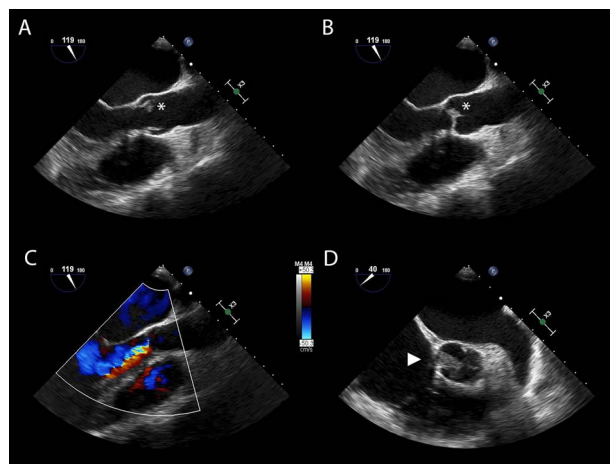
Transoesophageal echocardiography: Long-axis views of the left ventricular outflow tract and aortic valve in systole (A) and diastole (B) showing an echogenic mass in the non-coronary cusp of the aortic valve (indicated by asterisk). This was associated with moderate aortic regurgitation (C). (D) Short axis view of the aortic valve demonstrating the presence of a vegetation on the non-coronary cusp. Despite the presence of atrial fibrillation, the left atrial appendage was free of thrombus.
